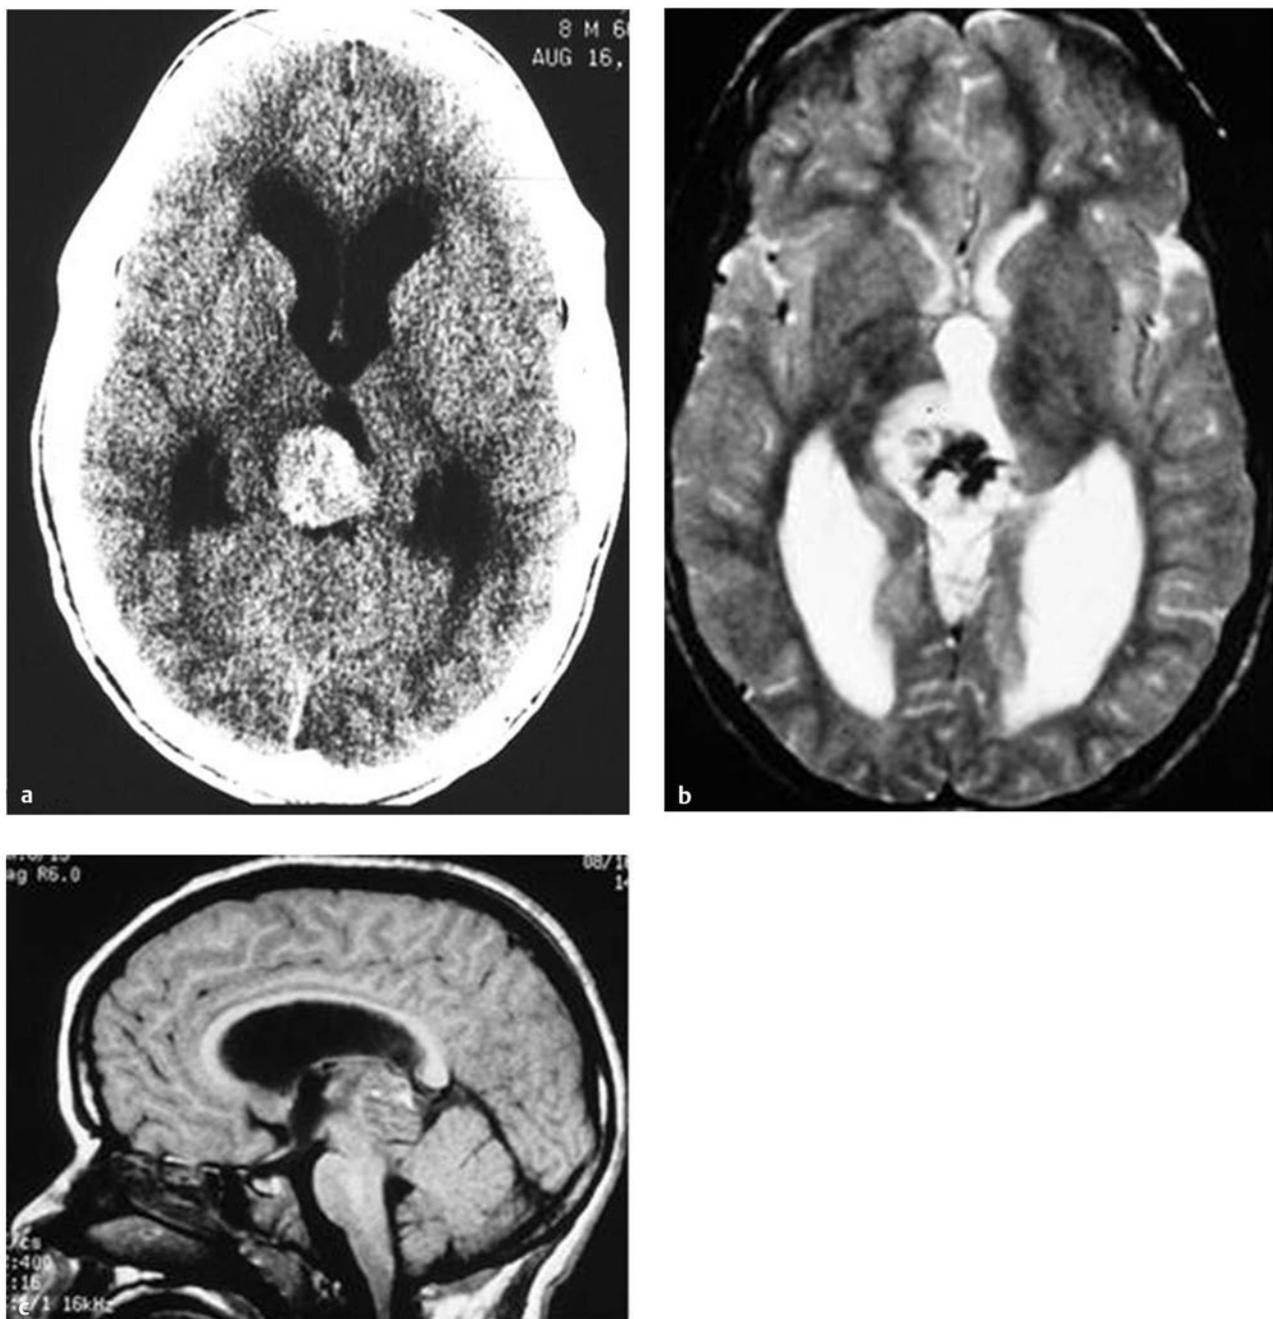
(a) Hemorrhagic choriocarcinoma is shown on precontrast computed tomographic scan, (b) T2-weighted axial magnetic resonance (MR) image, and (c) T1-weighted sagittal MR image.
